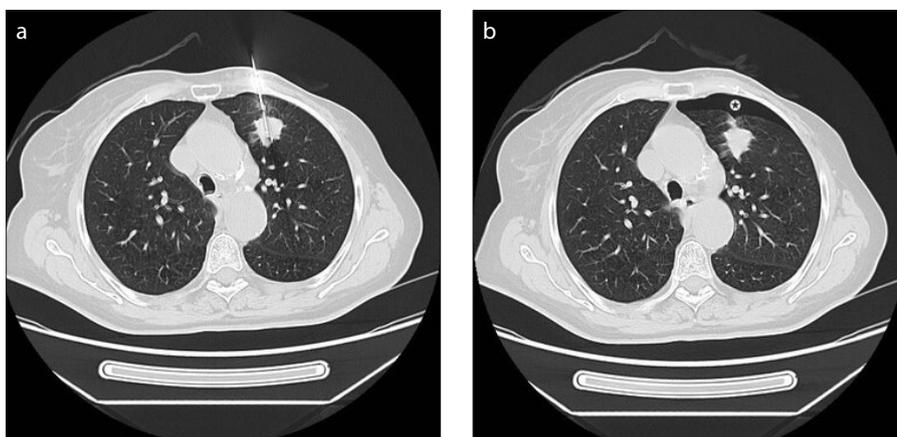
a, b. Axial CT image (a) shows the needle tip in a solid lesion in the upper left lung lobe. On the control CT scan (b) a minor post-biopsy pneumothorax is seen (white surrounded black star).
